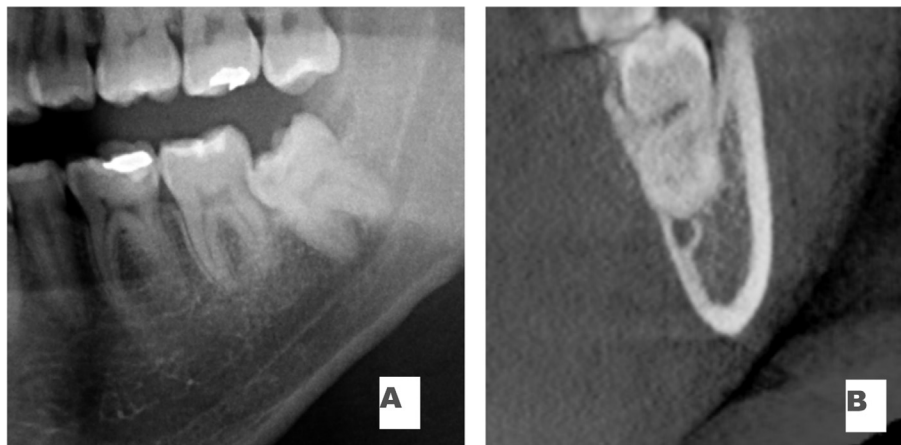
Cross sectional view of loss of canal cortication on cone beam computer tomography (CBCT) images.
